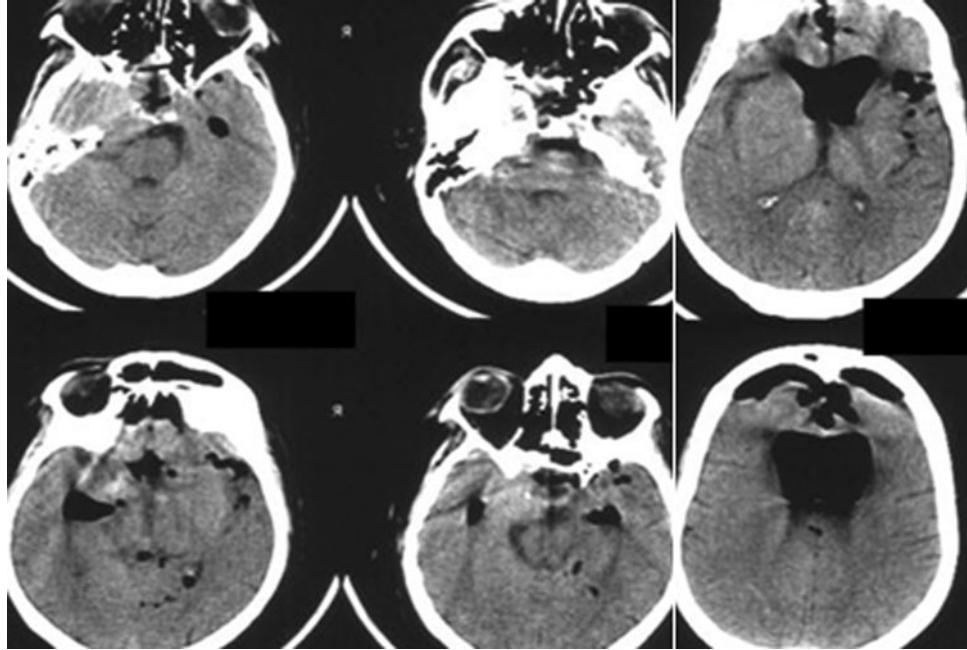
Postoperative CT-scans (second case)
